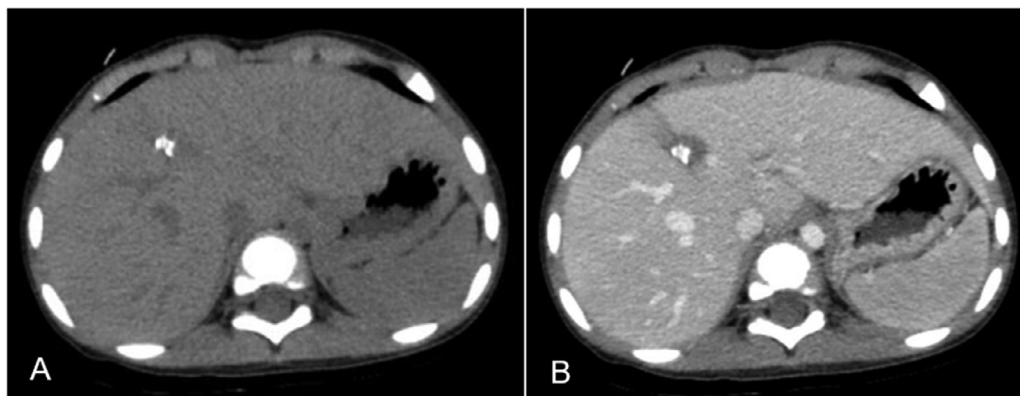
Computed tomography imaging 18 months after injury. Computed tomography imaging with (A) and without (B) contrast performed 18 months after injury revealed that the hematoma and aneurysm had disappeared, and the liver parenchyma was scarred, with nodular calcifications.
